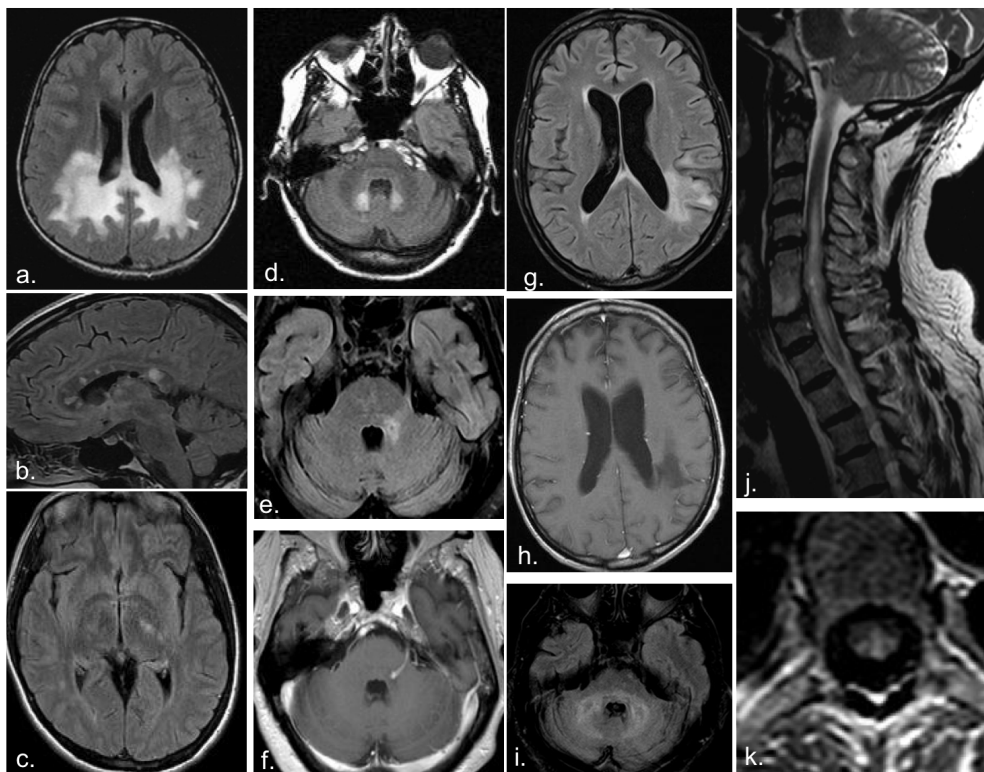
Imaging features of other multiple sclerosis mimics. a | Axial fluid attenuation inversion recovery (FLAIR) image showing features of the inherited leukodystrophies. Bilateral, confluent and symmetrical white matter lesions that spare the U-fibres (unlike in multiple sclerosis) are typical, and the predominantly posterior distribution shown is typical of X-linked adrenoleukodystrophy (arrows). b | Images of the typical features of Susac
